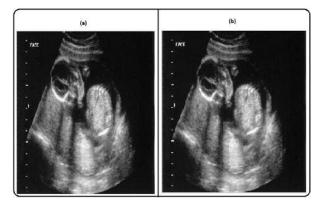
(a) The original watermarked Ultrasound image, (b)The image after up and down sampling attack
